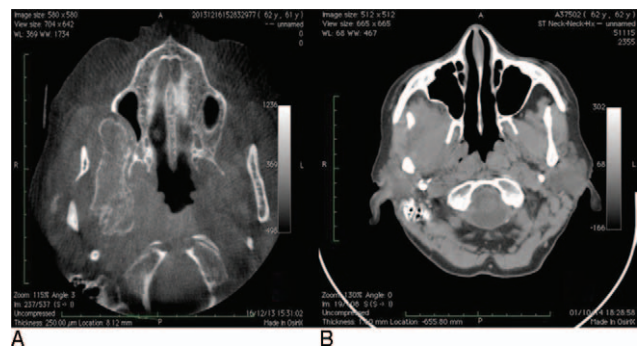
Axial plane. (A) CT examination. Preoperative image of a neoformation developed in the right pterygo-maxillary fossa. (B) CT examination. Postoperative image: no sign of lesion is clinically evident. CT, computerized tomography.
